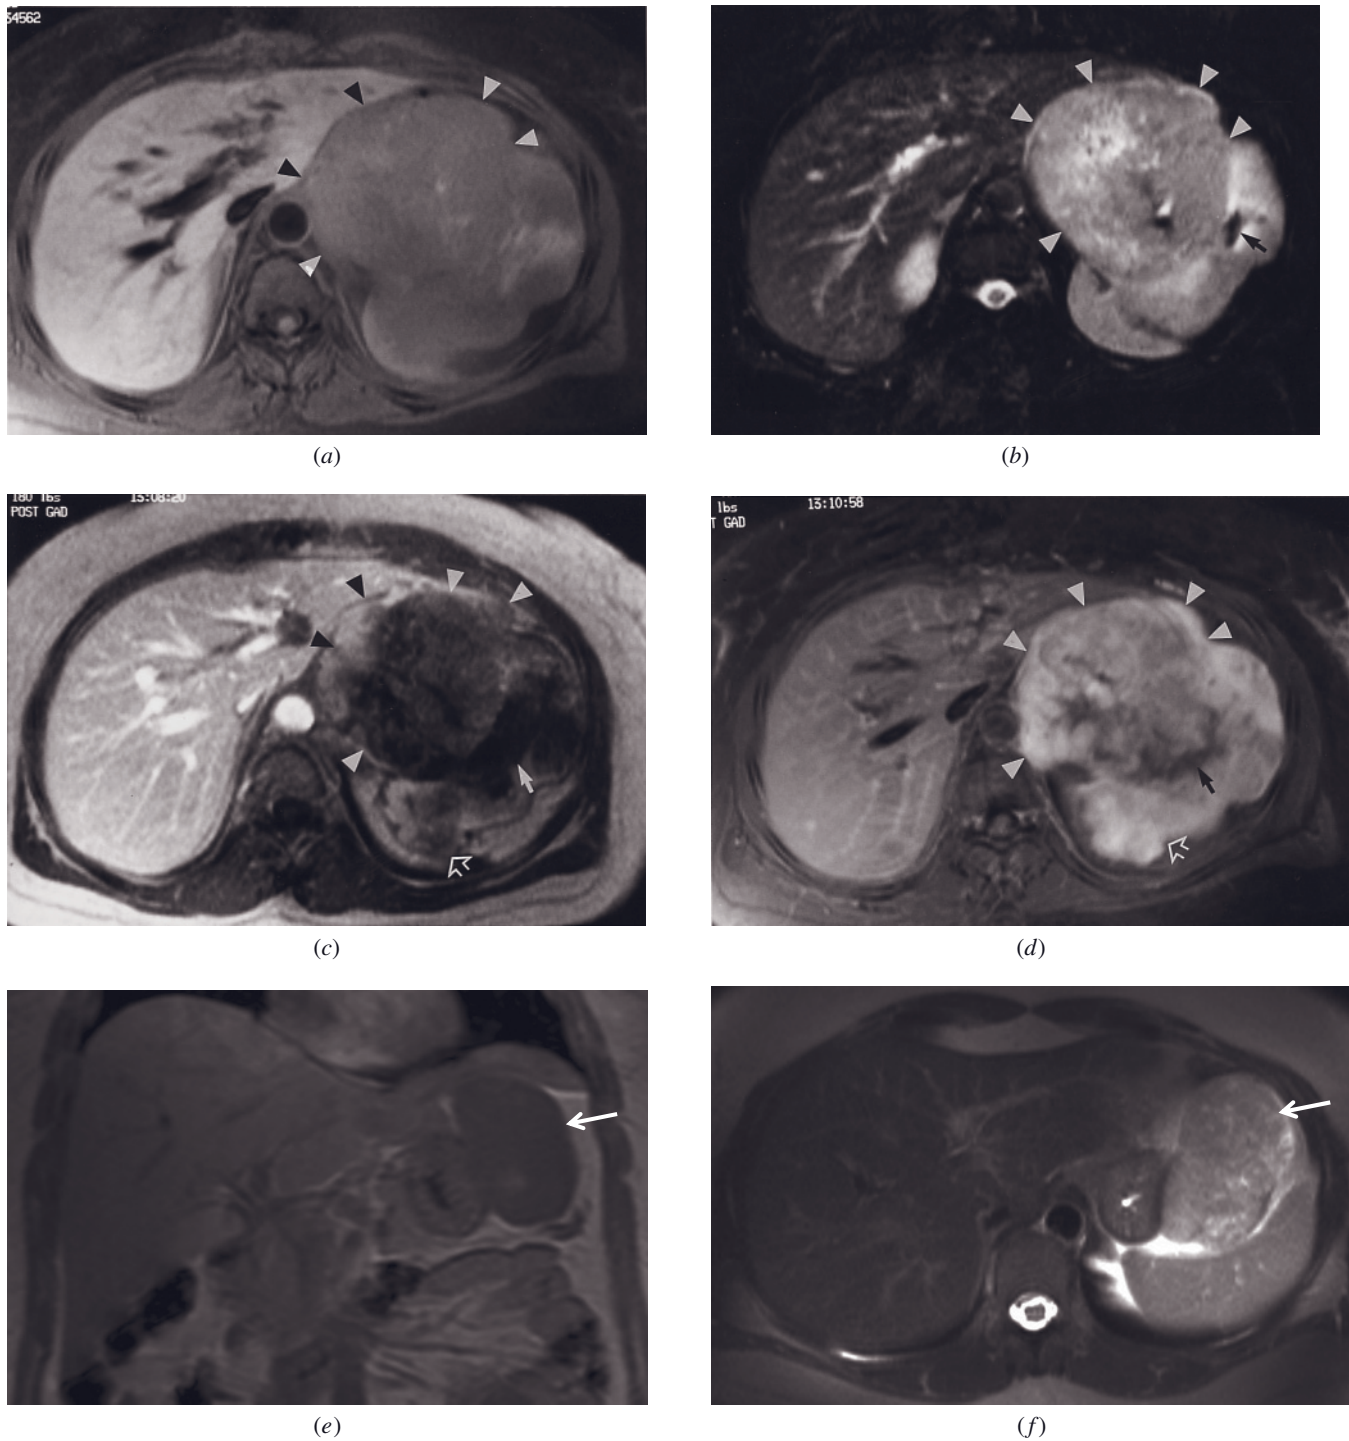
Gastrointestinal stromal tumor (GIST). T1-weighted fat-suppressed spin-echo (a), T2-weighted fat-suppressed spin-echo (b), 45-s postgadolinium SGE (c), and gadolinium-enhanced fat-suppressed spin-echo (d) images. A large exophytic GIST arises from the lesser curvature (arrowheads, a-d) and is contiguous with the spleen. The tumor is heterogeneous and high in signal intensity on the T2-weighted image (b) and enhances intensely (c, d). Enhancing tumor extends adjacent to the spleen (open arrow, c, d). Signal-void areas within the tumor are consistent with necrosis. Air within the gastric lumen is also signal void (solid arrow, b-d). Coronal T1-weighted SGE (e), transverse T2-weighted single-shot echo-train spin-echo (f), and transverse T1-weighted postgadolinium hepatic venous phase fat-suppressed 3D-GE (g) images at 3.0 T demonstrate an exophytic GIST (arrows, e-g) arising from the greater curvature of the stomach in another patient. The tumor shows low signal on T1-weighted image (e), mildly high signal on T2-weighted image (f), and mild enhancement on postgadolinium image (g). CT (b), T2-weighted fat-suppressed
